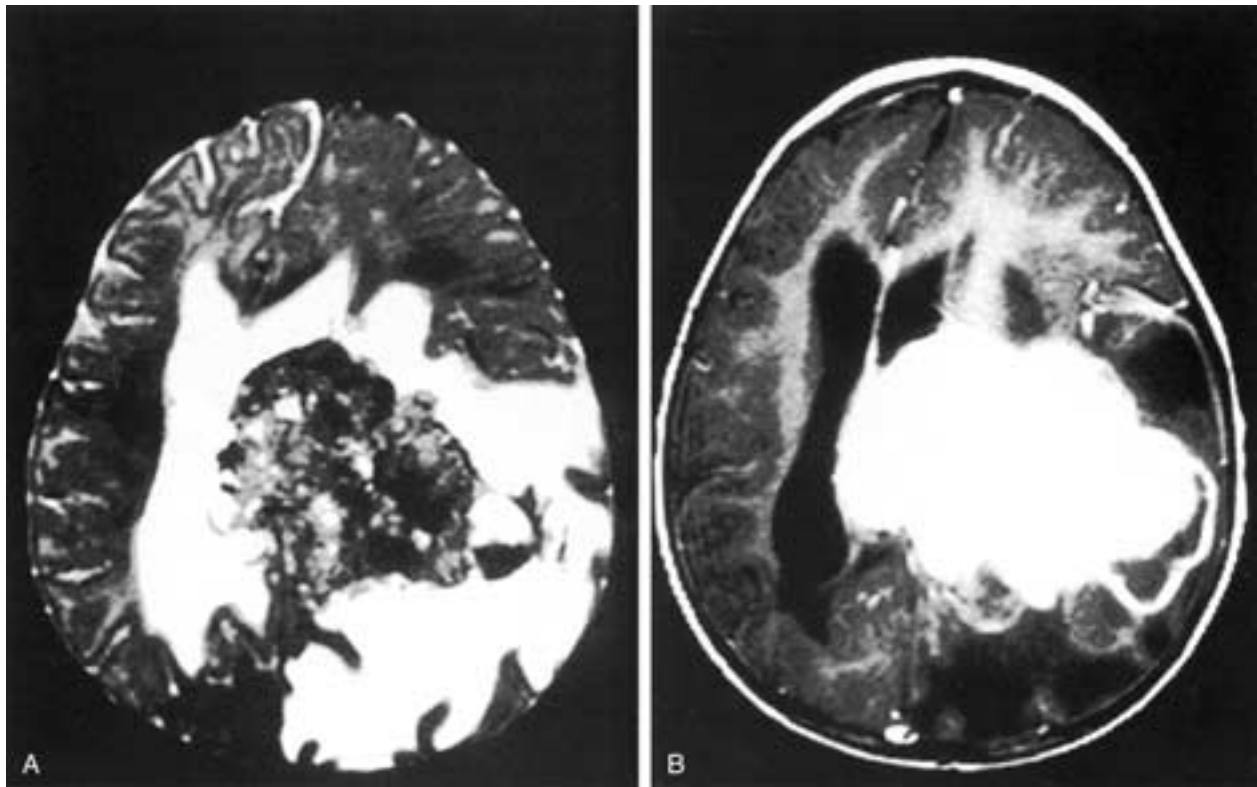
Choroid plexus carcinoma. Lateral ventricle, left side, invading the brain and producing right inferior quadrantic hemianopsia. A, Axial T2-weighted image shows a mass that is predominantly low in signal intensity, on its lateral margin is surrounded by vasogenic edema within the left cerebral hemisphere, and on its medial margin is within the displaced body of the left lateral ventricle. B, Axial T1-weighted image after gadolinium injection shows marked enhancement of the tumor mass.
